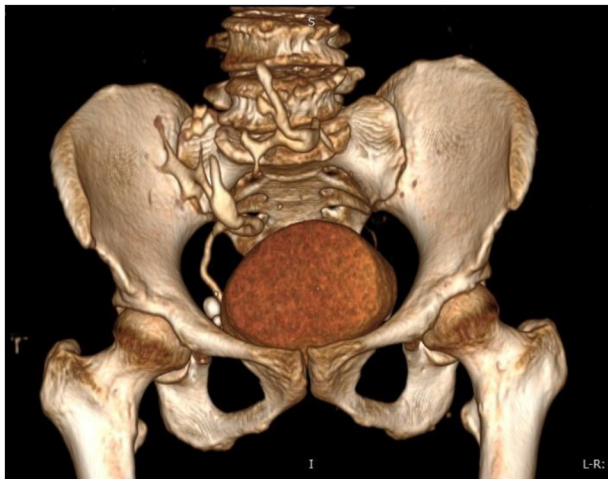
3D volume-rendered computed tomography (CT) image of the pelvis (excretory phase), demonstrating crossed fused renal ectopia (CFRE) in the right iliac region, with each moiety exhibiting a separate ureter.
